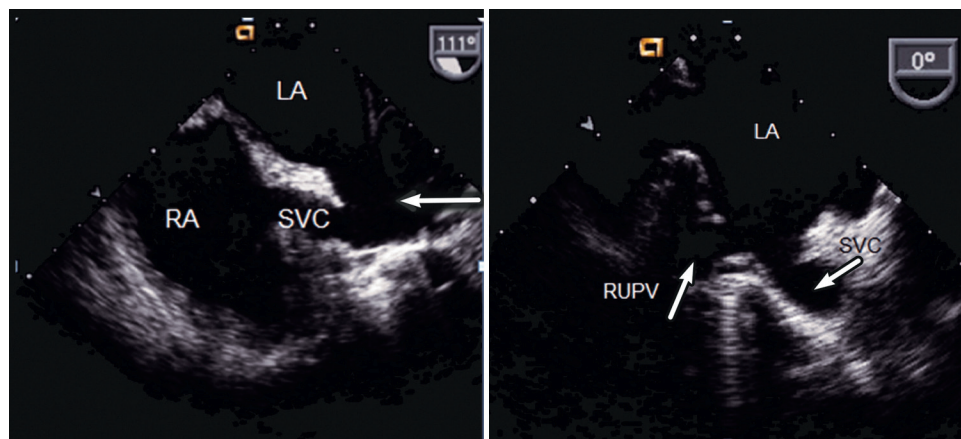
Transesophageal images of a sinus venosus ASD (SVC type) with anomalous drainage of the right upper pulmonary vein (RUPV). A confluence is created between the SVC, RUPV, and adjoining atria. LA = left atrium; RA = right atrium.
